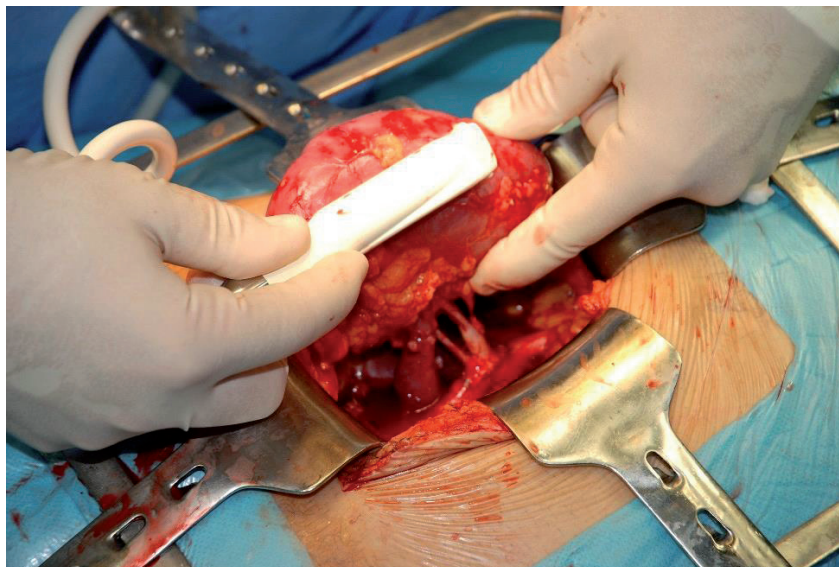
Doppler ultrasound examination — intraoperative view.
